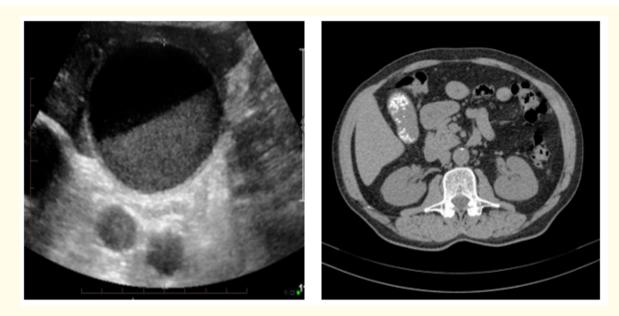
An example of visualization of BS during studies of the abdominal organs using ultrasound (left) and MRI (right). BS-1 is presented (hyperechoic inclusions are visualized in the gallbladder cavity, which are detected when the patient's body position changes) [8].
